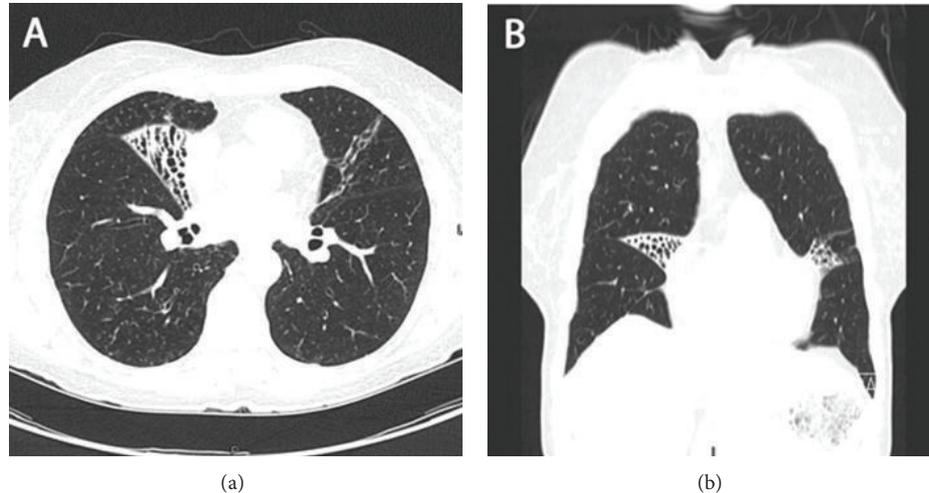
Nodular/bronchiectatic form of nontuberculous mycobacterial lung disease. Axial (a) and coronal (b) computed tomography images demonstrating focal bronchiectasis in both the right middle lobe and lingula, characteristic of Lady Windermere syndrome [38].
